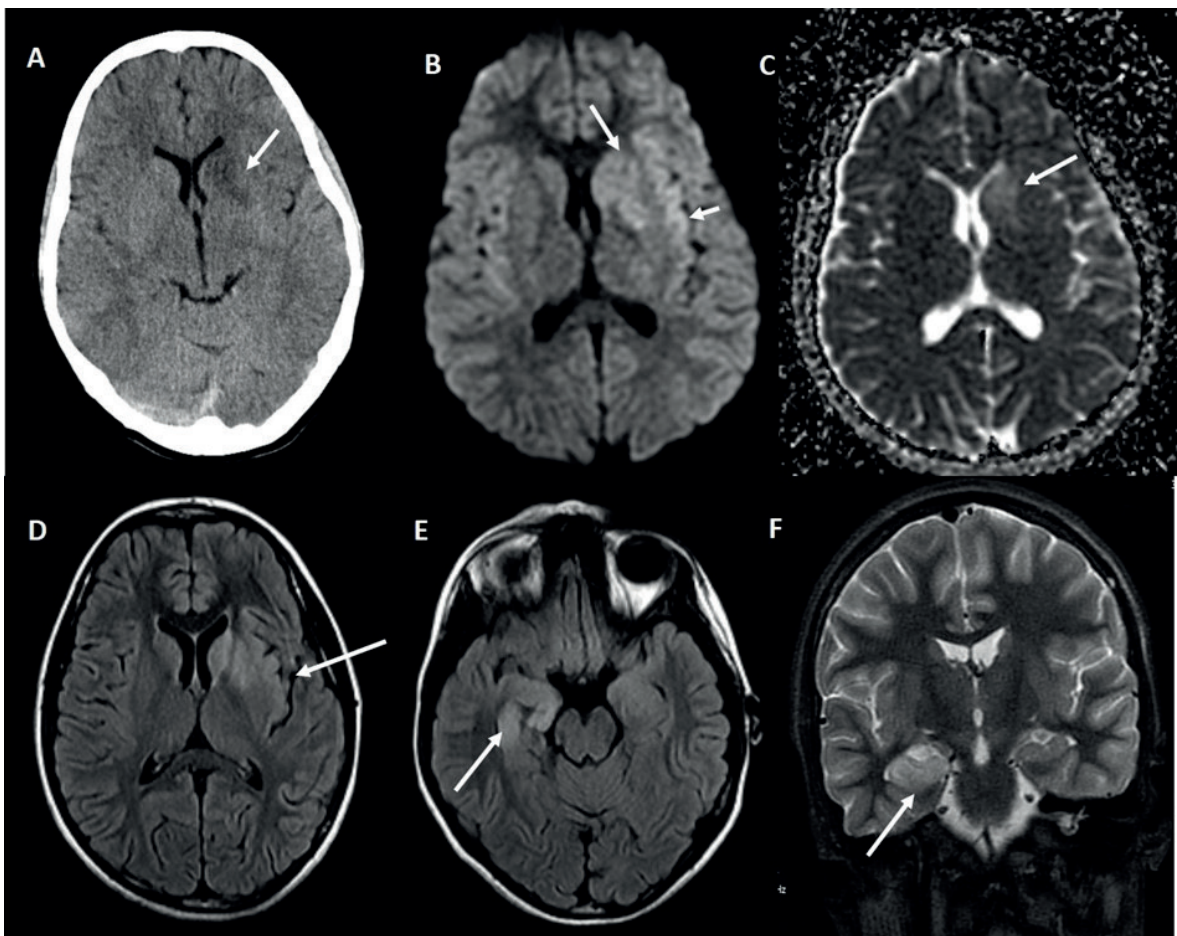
On non enhanced CT scan (A) slightly hypodense area involving left corpus striatum is seen (arrow). MR imaging of the brain demonstrates: mild hyperintensities in left corpus striatum (long arrow) and insula (short arrow) on DWI (B), but no restricted diffusion on the corresponding ADC map (C). On axial FLAIR images; hyperintensities and mild expansion involving left insula and corpus striatum (D), right medial temporal lobe, left temporal lobe and right inferior frontal lobe (E) is demonstrated. On coronal T2 image hyperintensity and expansion of right hippocampus is better visualized (F).
